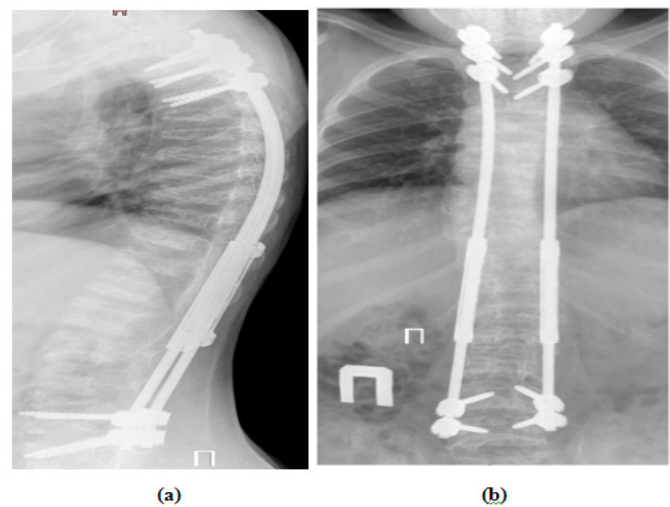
a) Postoperative spine radiographs showed correction kyphoscoliotic deformity - «growing rod» construction. b) For 5 years the patient performed staged operations. final correction kyphoscoliotic deformity - posterior fusion Th2-L5. Posterior spondilodesis.
